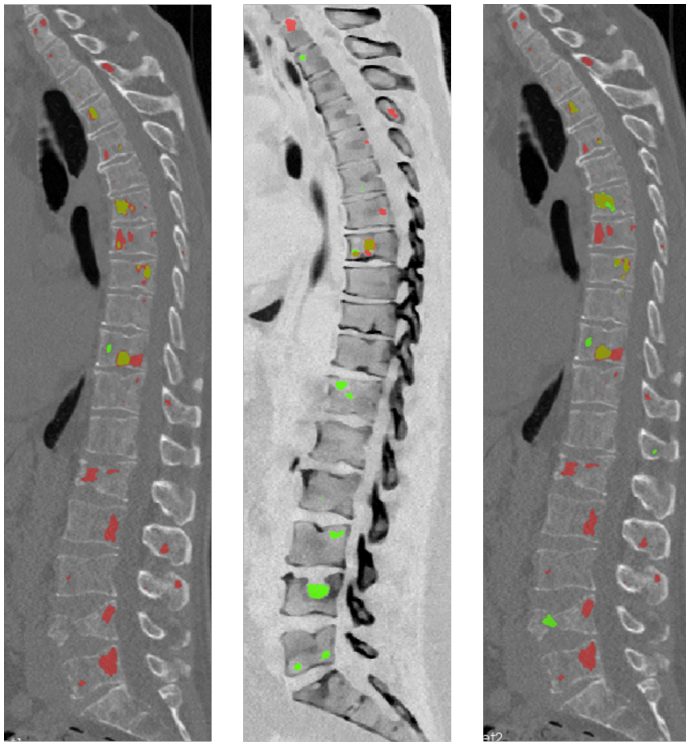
CT scans with labeled lesions (green color) and with predicted lesion (mix of red and green color). From left conventional, calcium-suppressed with index 25, monoenergetic 40 keV CT scans
